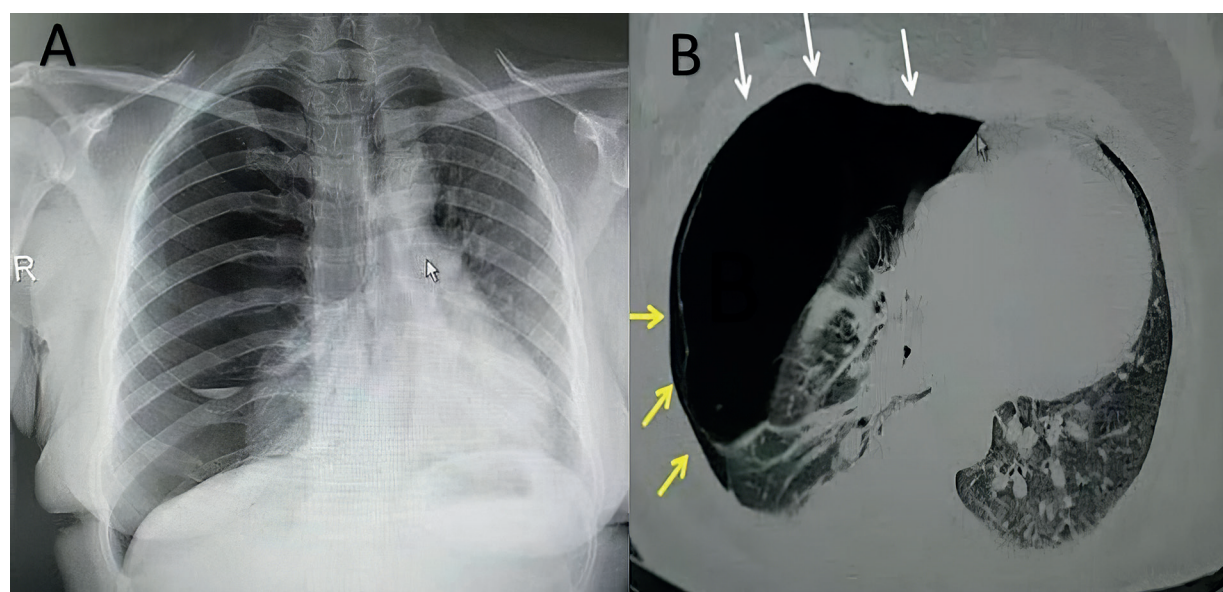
Posteroanterior chest roentgenogram (A) shows giant radiolucent bullae formation on right lung. Also, giant bullae formation (white arrows) and adjacent minimal pneumothorax (yellow arrows) are seen in the axial thorax CT (B) image taken in the mediastinal window.
